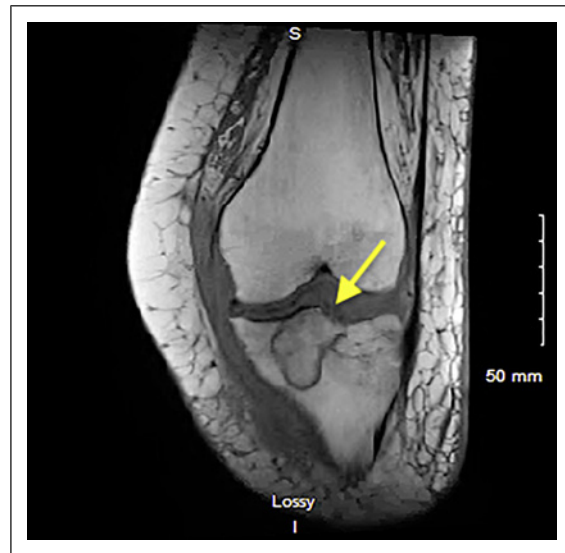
MRI left knee with anteromedial 1.8 × 3.9 cm enhancing fluid collection concerning for abscess.
